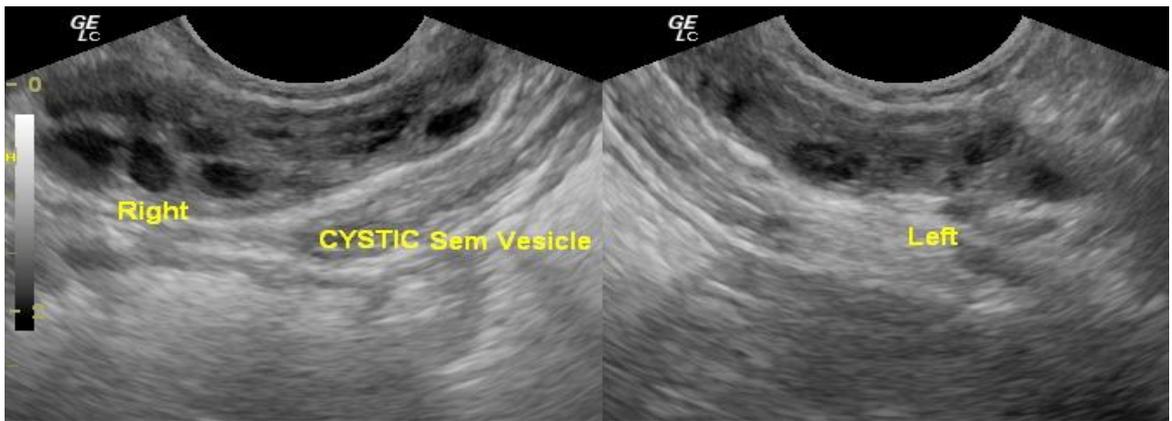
Image of ultrasound scanning of Seminal vesicle with Bilateral cysts.
